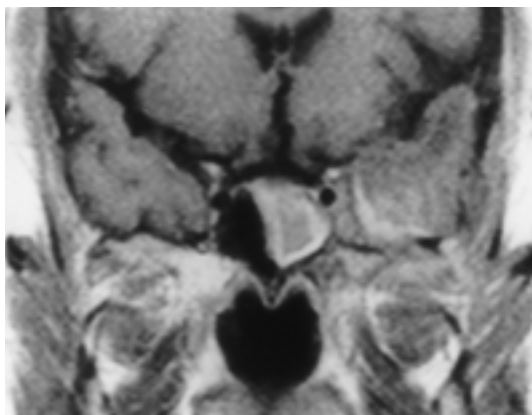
Case 1 (42/M) with left septic cavernous sinus thrombosis. Enhanced coronal T1-weighted image shows enhancement on left temporal lobe and adjacent meninx. Inflammatory change in sphenoid sinus is well visualized.
